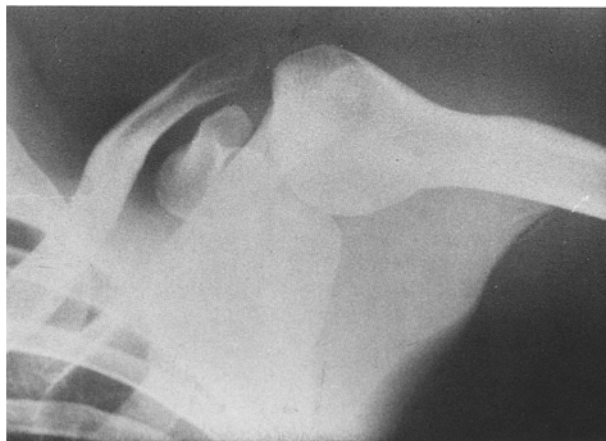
Follow-up radiograph with slight residual varus angulation
